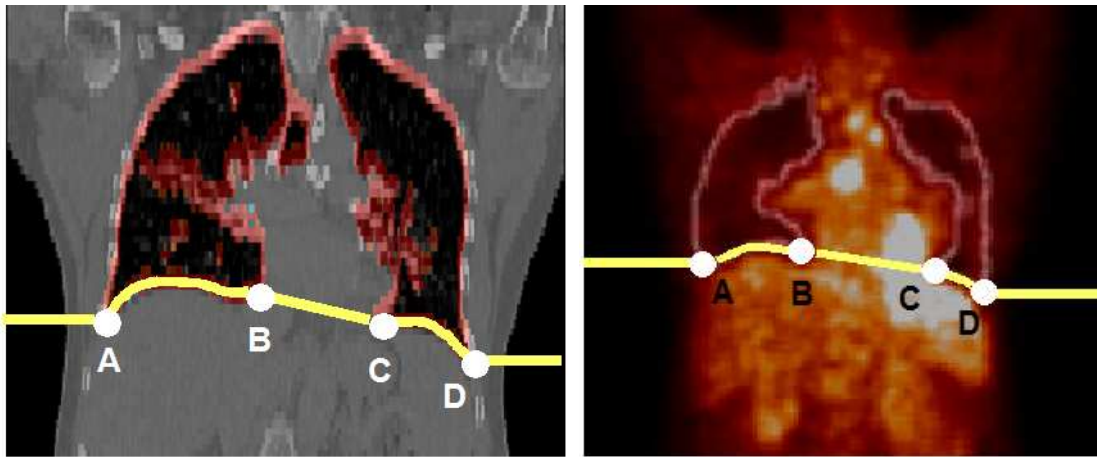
Landmarks (points *A*, *B*, *C* and *D*) and upper bound obtained from the lungs in CT (left) and emission PET (right) images in order to built liver and kidneys ROI.
